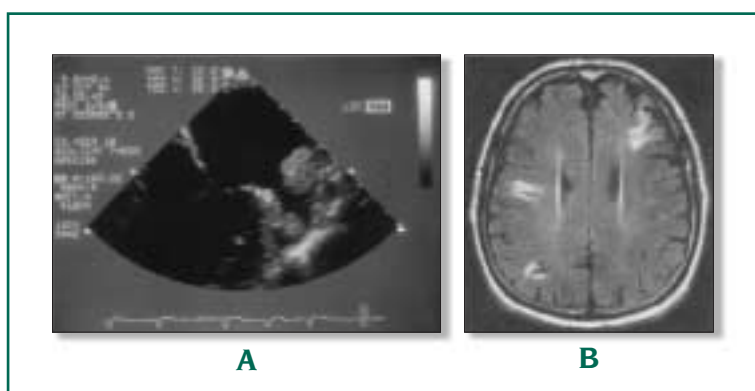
(A) Thrombi in the left atrial appendage. (B) Magnetic resonance image of multiple cerebral infarcts.
